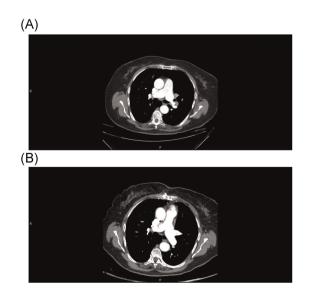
Computed tomography angiography showing the pulmonary embolism pre-op (A) and post-op (B) in axial view
